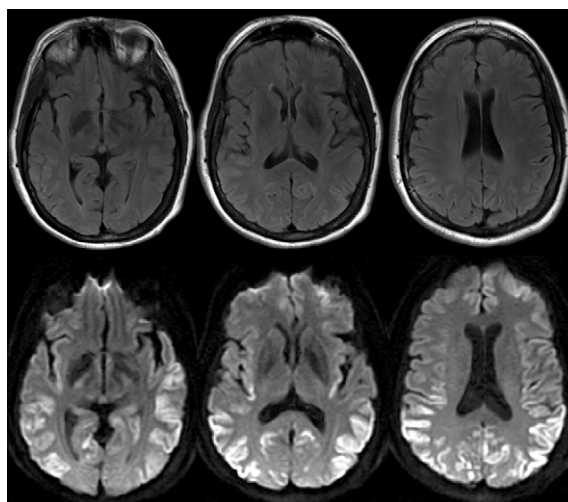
FLAIR and DWI MRI in a patient with sCJD
